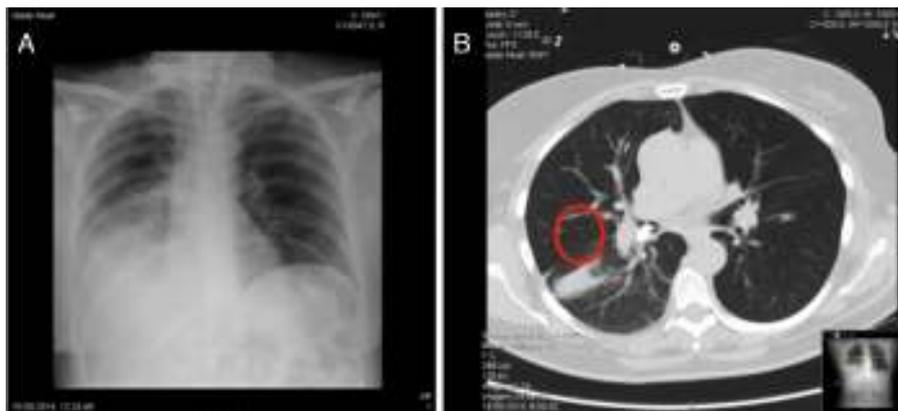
Chest X-ray (A) showing atelectasis and pulmonary infiltrates in right base consistent with a tooth; CT scan (B) showing opacity in the right lower lobe and 13 mm endobronchial foreign body.
